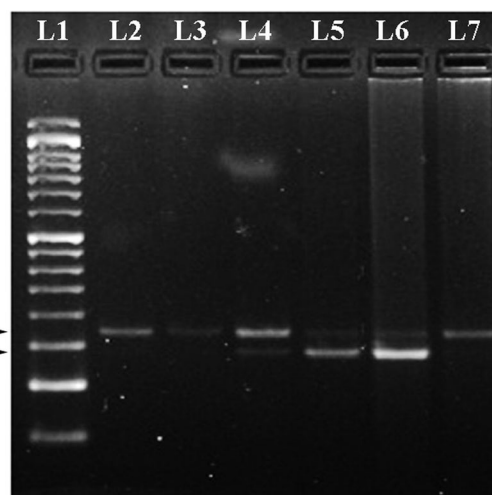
Agarose gel electrophoresis for the rs662 polymorphism of paraoxonase 1 (PON1) gene. The 214 bp bands correspond to wild homozygous QQ genotype produced one fragment, while 190 bp, 214 bp, and 24 bp corresponds to heterozygous QR that produced 3 fragments. The 190 bp and 24 bp corresponds to variant homozygous RR genotype produced 2 fragments. The 24 bp was invisible in the gel due to its fast migration speed. About 50 bp ladder marker (L1), QQ genotype (L2, L3, L7), CT genotype (L4, L5), and RR genotype (L6)
